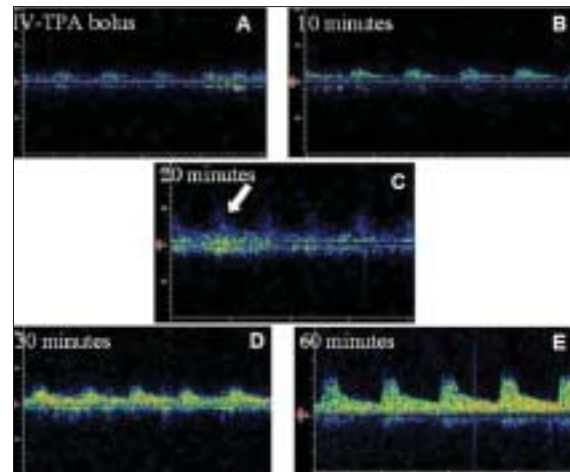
Real-time transcranial Doppler spectral traces during ultrasound-assisted thrombolysis (case 2). Minimal (TIBI grade 1) signals were noted at the onset (A) and 10 min after initiation of IV thrombolysis (B). Recanalization started 20 min after IV TPA bolus, as noted by faint signals of improved flow (C), associated with simultaneous clinical improvement. Flow signals became stronger (D) and were maintained (TIBI grade 5) at the end of IV thrombolysis.
